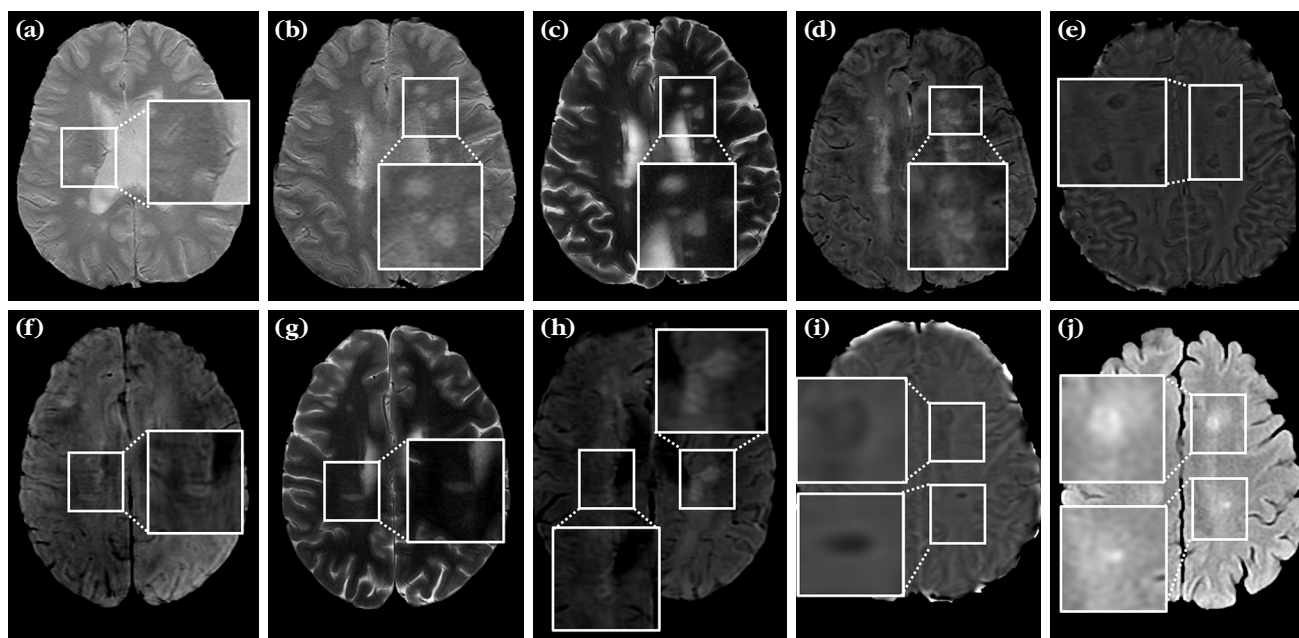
Central vein sign and PRL in MS and RIS. (a, b) Central vein sign visualized on 1.5T SWI, (c) Dot sign and CVS observed on 3T T2-weighted T2W, (d) Dot sign on 3T SWAN sequence, (e) Paramagnetic rim lesion on 3T SWAN-filtered phase image, (f, g) Central vein sign in RIS on 3T SWAN and T2W sequences, respectively, (h) Central vein sign on 3T SWAN, (i, j) Paramagnetic rim lesions visualized on 3T SWAN and corresponding FLAIR images.
